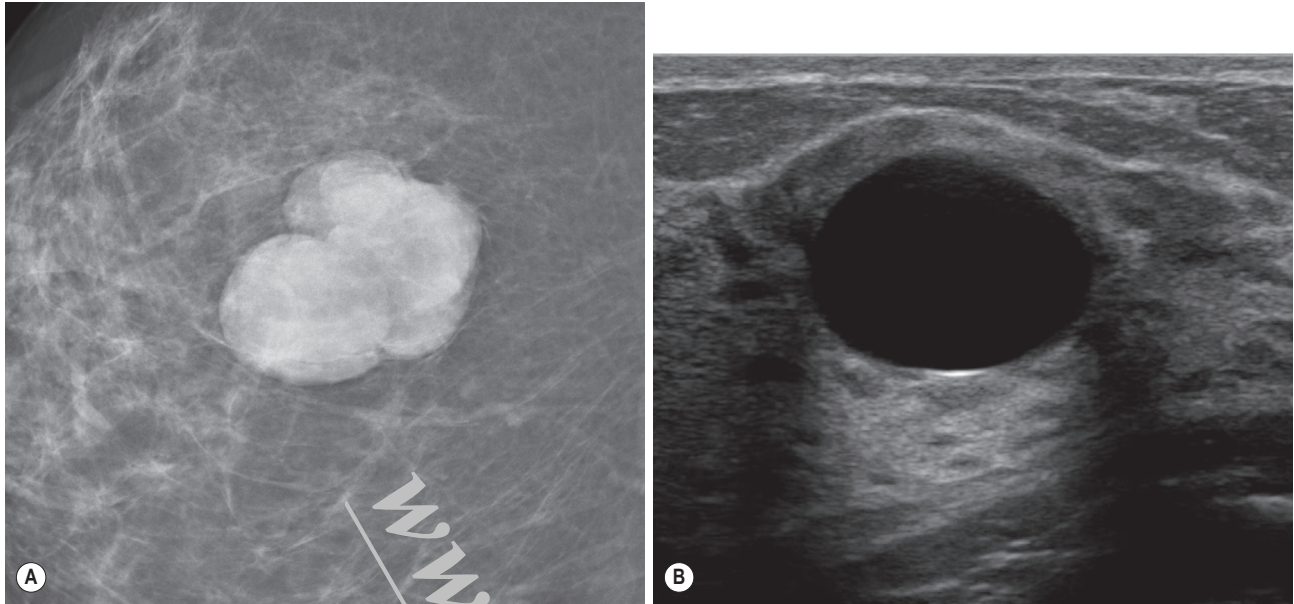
Cyst. (A) A well-defined rounded mass, with an associated lucent halo typical of a cyst. (B) The absence of internal echoes and the posterior enhancement of the ultrasound beam are diagnostic of a cyst.
